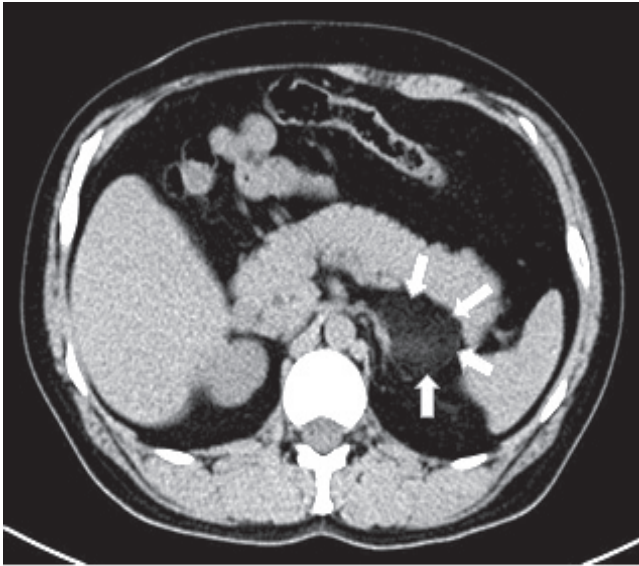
CT image of the adrenal glands.
